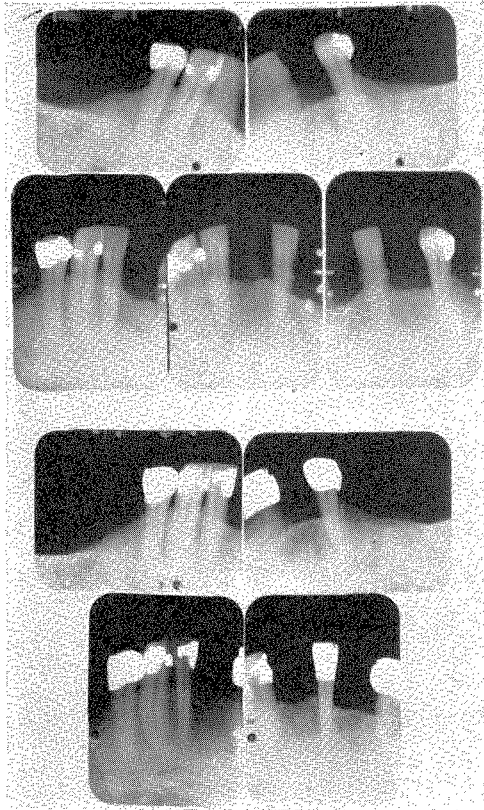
A comparison of the radiographs taken in 1940 (above) and 1950 (below). The bone structure was stable over this ten-year period.
